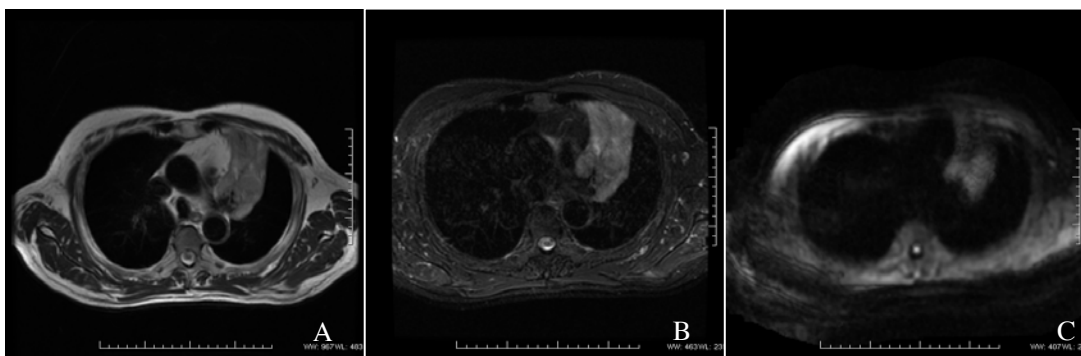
A : T2WI image, tumor and atelectasis can be distinguished. B: STIR image, the interface of tumor and atelectasis is clearer. C: DWI image, highlight the central tumor.
